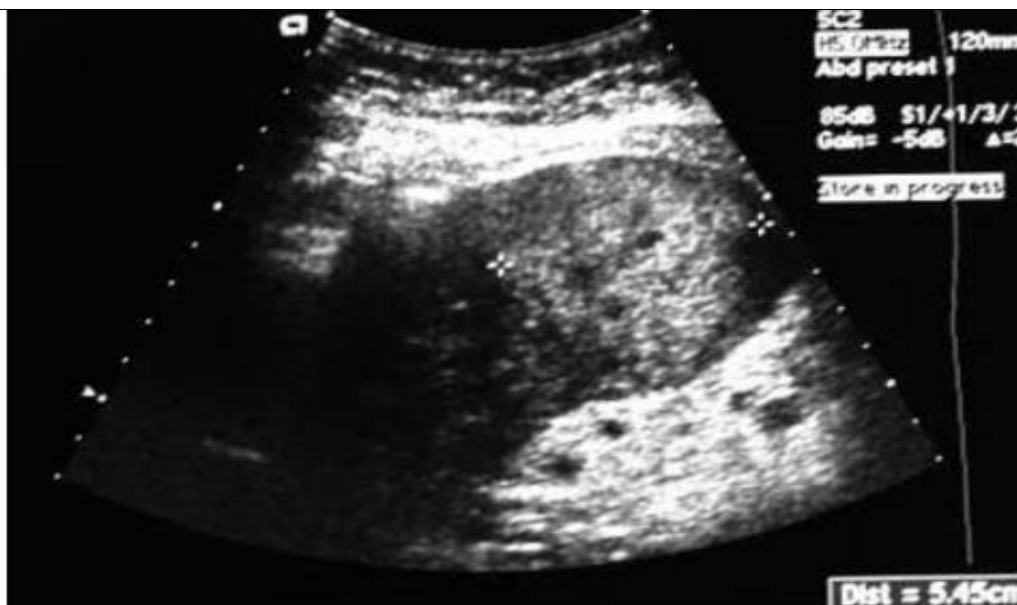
Ultrasound shows hyperechoic mass representing HCC[12].
